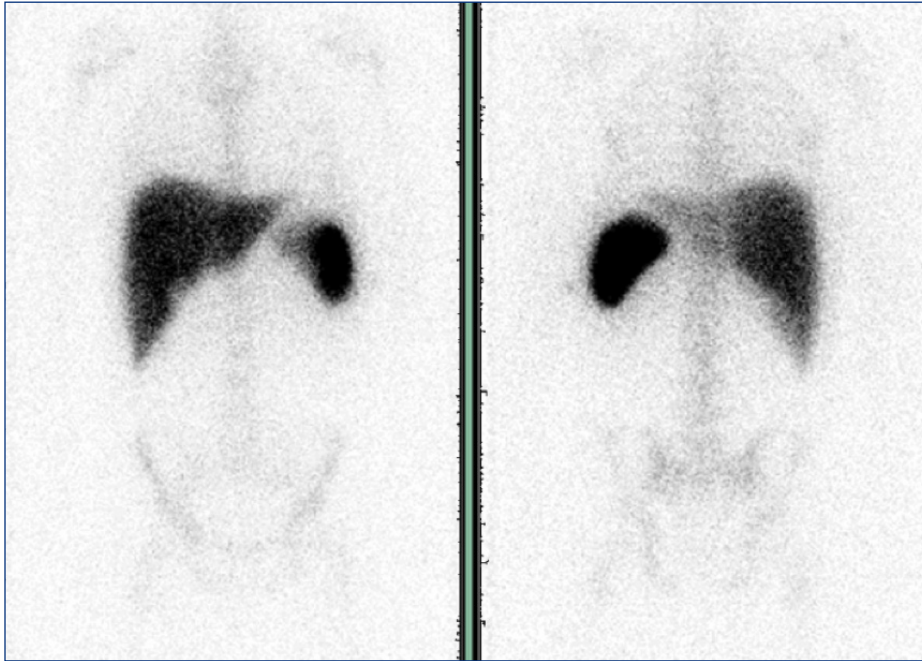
Maximum intensity projection Indium-111 labeled leukocyte scan image (A) and axial, coronal, and sagittal Indium-111 labeled leukocyte SPECT, (B-D, respectively) and fused SPECT/CT images (E-G, respectively) show no increased uptake in the region of the SMA (red arrows) in the area of abnormality seen on prior contrast-enhanced CT.
